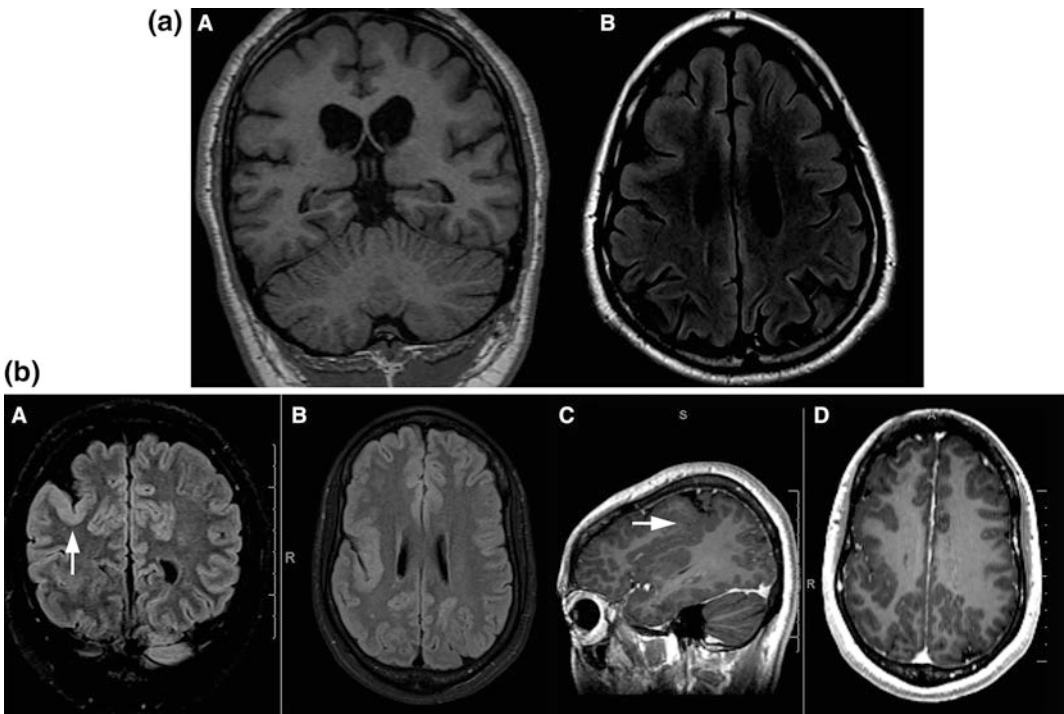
a Coronal 3D T1-weighted (A) and axial FLAIR MRI (B) demonstrate broad, simplified gyri with relatively shallow sulci in the bifrontal regions compared to the temporal and parietal regions consistent with pachygyria. b Coronal and axial FLAIR (A and B), sagittal, and axial post-contrast 3D T1 (C and D) MRI
